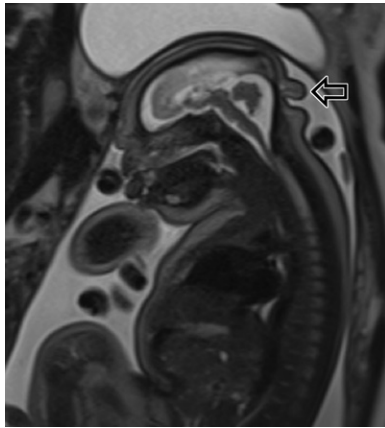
Posterior fossa abnormalities and microcephaly in a 37-week fetus with Zika virus infection acquired in the first trimester of gestation of a 33-year-old mother. (a) Coronal T2-weighted MR image shows microcephaly and cortical atrophy, as well as smoothness of the brain surface and ventriculomegaly (\*). (b) Sagittal midline T2-weighted MR image shows a hypoplastic cerebellum and thin brainstem (arrow).
